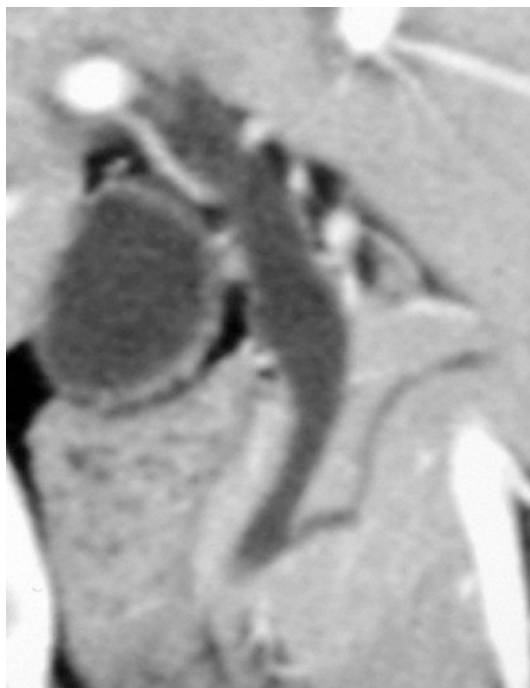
MD-CT image of complex type
